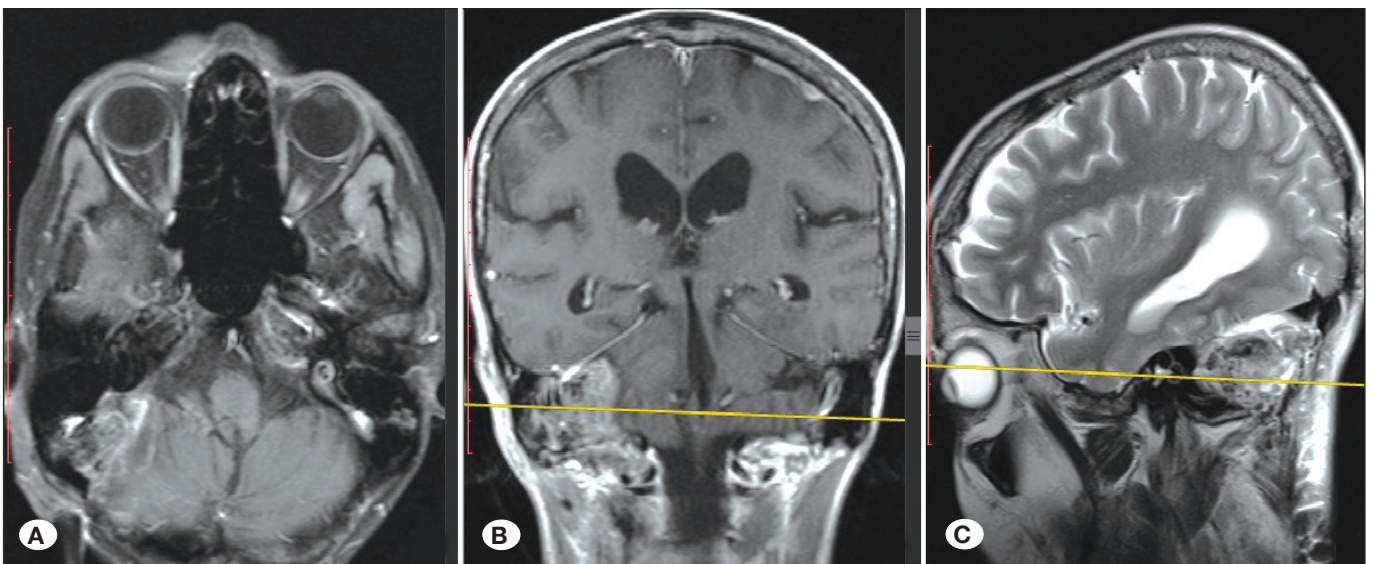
Early postoperative MRI from “Case 1”; A) axial T1W, B) coronal T1W, and C) sagittal sequences.
